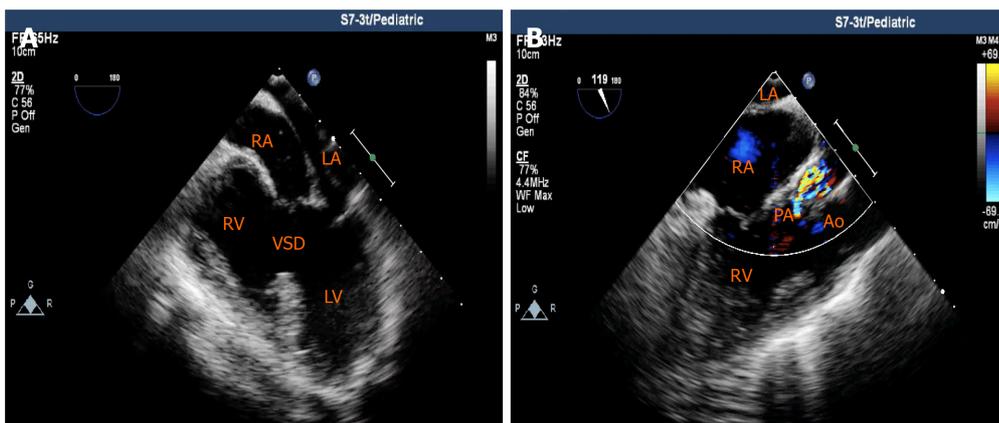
Intraoperative transesophageal echocardiogram. A: Ventricular septal defect was evident; B: Both the aorta and the pulmonary artery evolved from the right ventricle, with significant pulmonary artery stenosis. LA: Left atrium; LV: Left ventricle; RA: Right atrium; RV: Right ventricle; Ao: Aorta; PA: Pulmonary artery; VSD: Ventricular septal defect.
